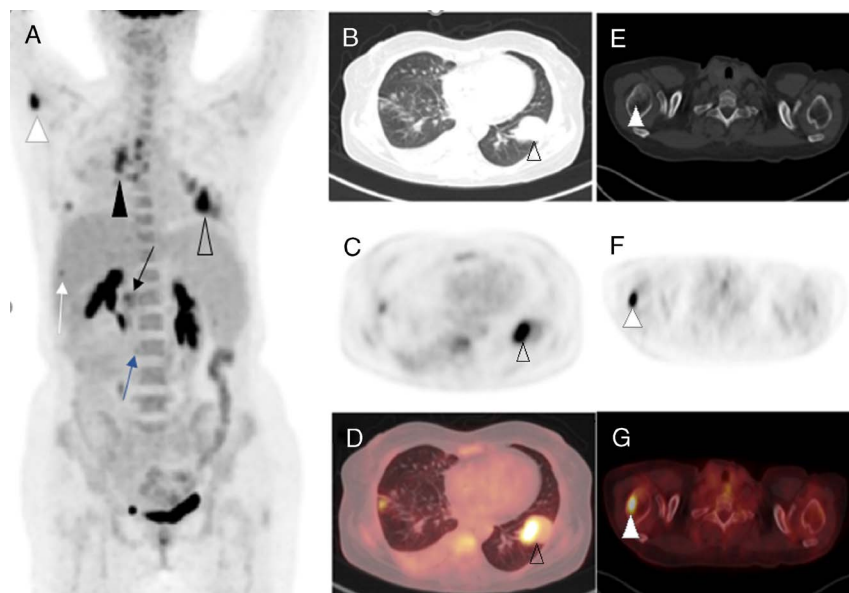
A 52-year-old woman with a history of adenocarcinoma of the ampulla of Vater who underwent partial pancreatectomy and chemotherapy was referred for ^{18}F -FDG PET/CT scan. The MIP image of ^{18}F -FDG PET (A) showing tumor recurrence (black arrow) as well as metastases in the lungs (blank arrowhead), mediastinal (black arrowhead) and retroperitoneal lymph nodes (blue arrow), liver (white arrow), and right humerus (white arrowhead). Axial view images showing pulmonary metastasis (B, CT; C, PET; D, fused PET/CT) and metastasis to the right humerus (E, CT; F, PET; G, fused PET/CT).
